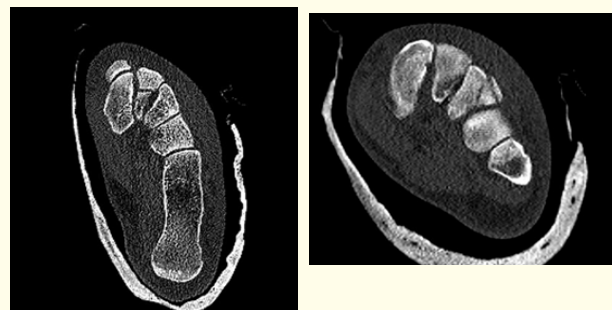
CT scan with fractures to the cuneiforms II and III.
